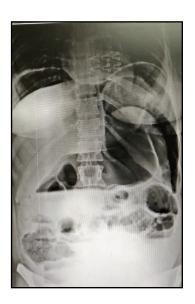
X-ray FPA showing gas under diaphragm with dilated stomach and bowel
